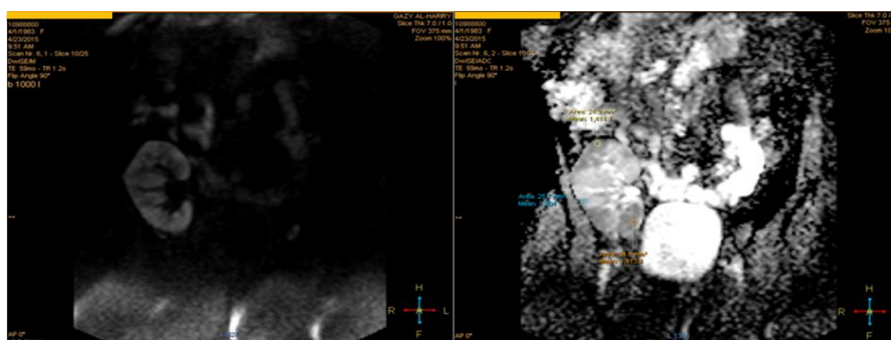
Coronal DWI and ADC for patient with ATN of renal allograft, the ADC map showing heterogeneous/ patchy mosaic pattern with low mean ADC values of renal parenchyma.
